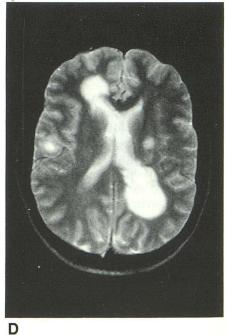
A, A noncontrasted CT obtained at the onset of the patient's illness (at outside hospital) demonstrates periventricular white matter (PVWM) low-density lesions, especially in the right frontal region (*arrow*).
